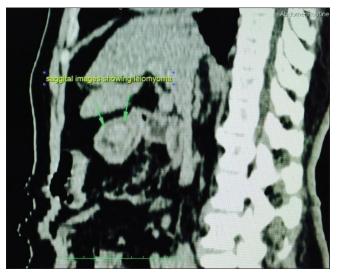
Contrast-enhanced computed tomography image showing the 2 cm by 2 cm mass in the pyloro-antral region (long arrows)
